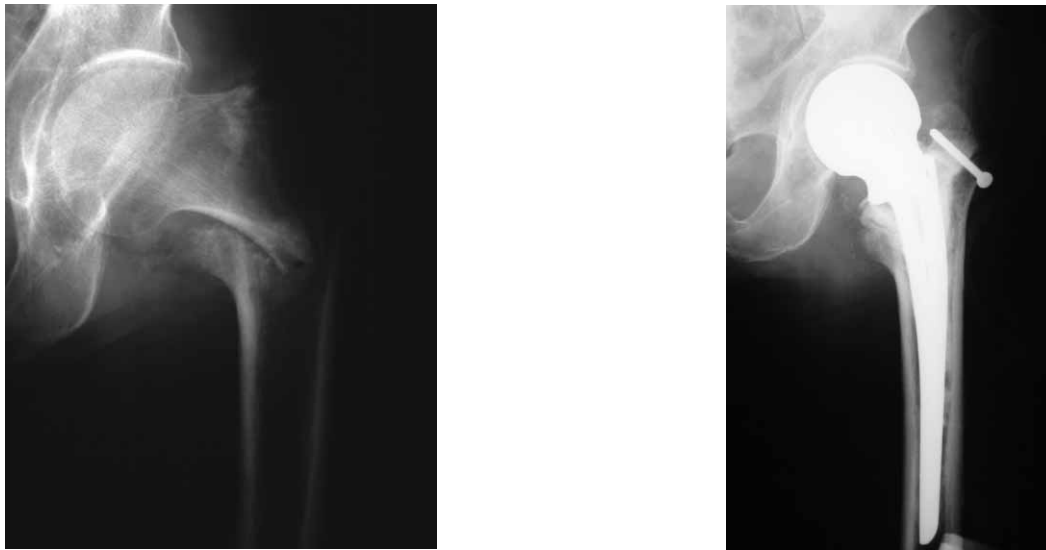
a) Preoperative AP radiograph of the hip shows unstable trochanteric femoral fracture with fracture of greater trochanter, and b) Postoperative AP radiograph of the same hip after implantation of the partial endoprosthesis and fixation of the greater trochanter with a screw.
